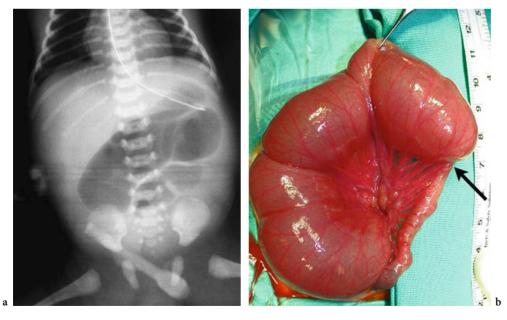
Jejunal atresia. a Supine radiograph shows a few dilated, air-filled intestinal loops, about four "bubbles", which indicates a high obstruction. b Surgical image demonstrates the location of the atresia (*arrow*), the dilated proximal jejunum, and the small caliber of the bowel distal to the atresia
